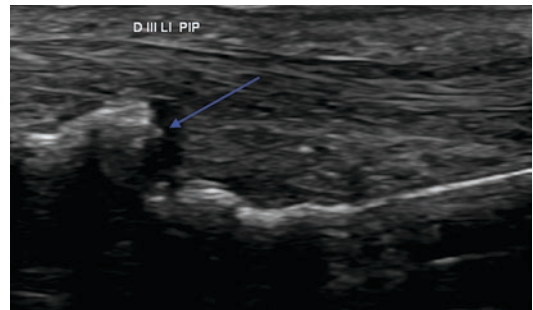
Sonographic finding in a capsulitis
